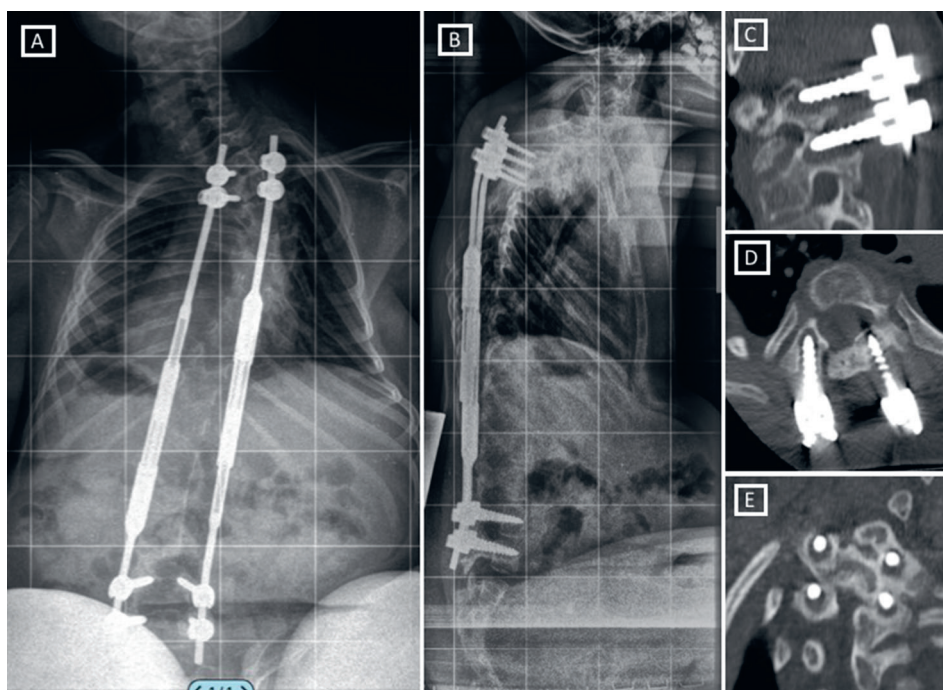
Loss of proximal fixation of MGCR. Plain whole spine X-rays in postero-anterior (A) and lateral (B) projections. The CT images of loosened screws in sagittal (C), axial (D) and coronal (E) views
